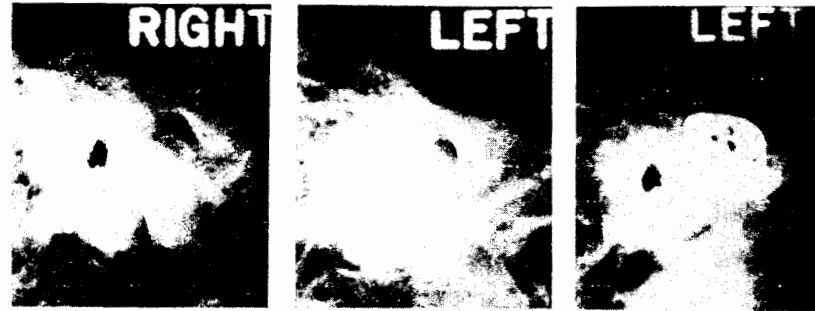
Case III—Pre-operative X-ray of right mandibular joint showing normal joint. FIG. 16. Case III—Pre-operative X-ray of left mandibular joint showing loss of articular space, and steep articular eminence. FIG. 17. Case III—Post-operative X-ray of left mandibular joint with prosthesis in place.
